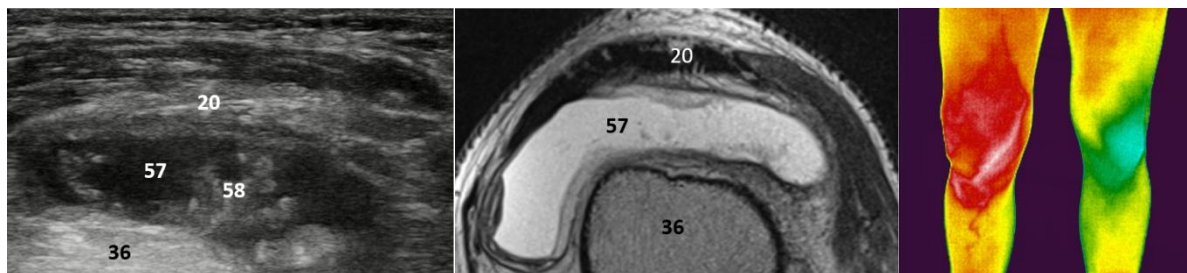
Sono, Fig.5b.MRI, Fig.5c. TMV. Sono, MRI: villous synovial hypertrophy and hypoechogenic filling in the recessus suprapatellaris. TMV: high temperature activity of the right knee. 20.tendo m. recti femoris, 36.femur, 57.hydrops, 58.synovia.
